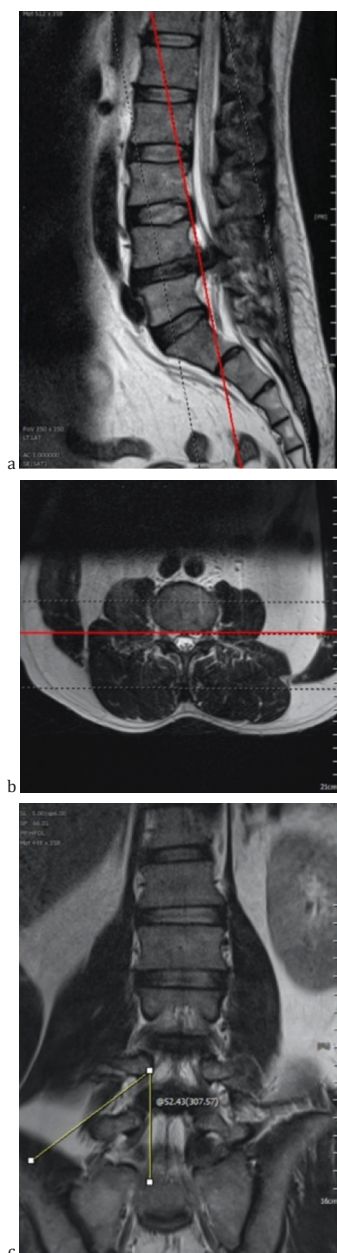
Lumbar spine MRI image that shows sagittal (a), axial (b), and coronal (c) to show nerve roots direction to measurement.
